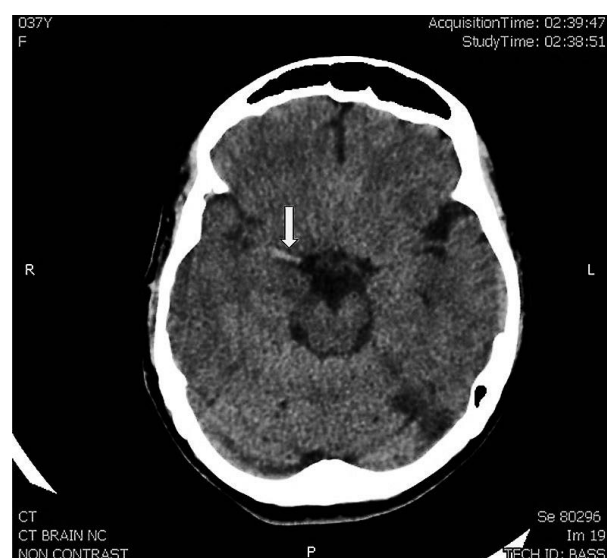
Axial non contrast CT brain: dense MCA signs (cord sign) on the right MCA (arrow).
